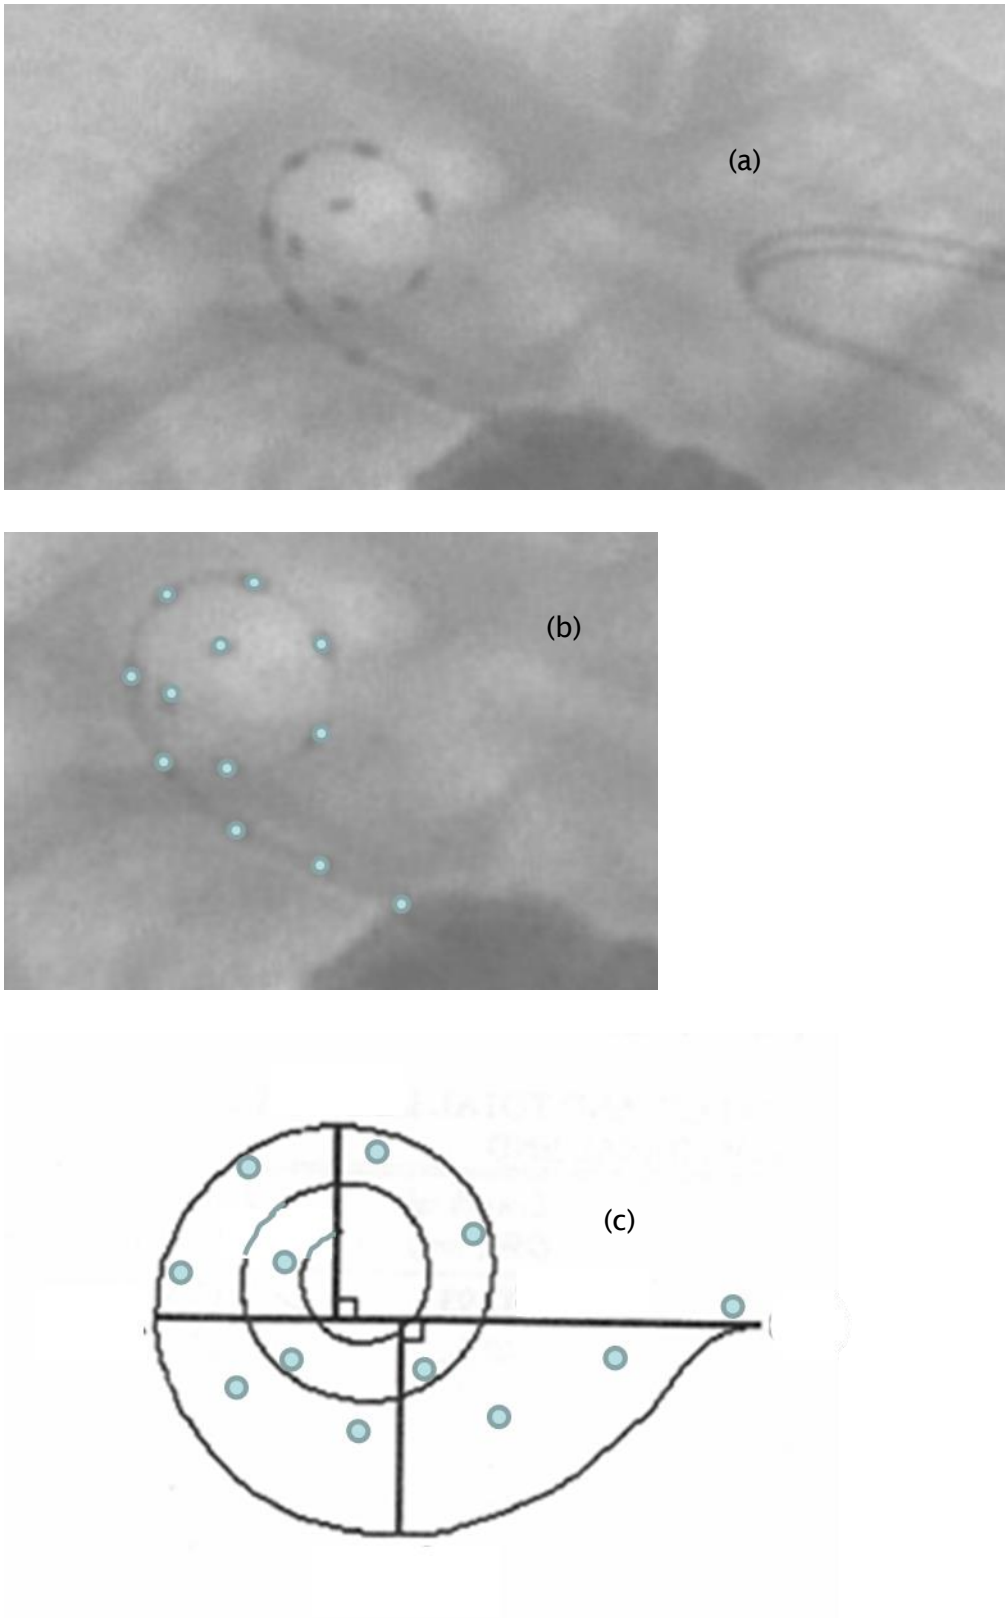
(a) X-ray for P12; (b) X-ray with electrode positions indicated (c) electrode positions superimposed on the shape of the template from Kawano *et al.* (1996)
